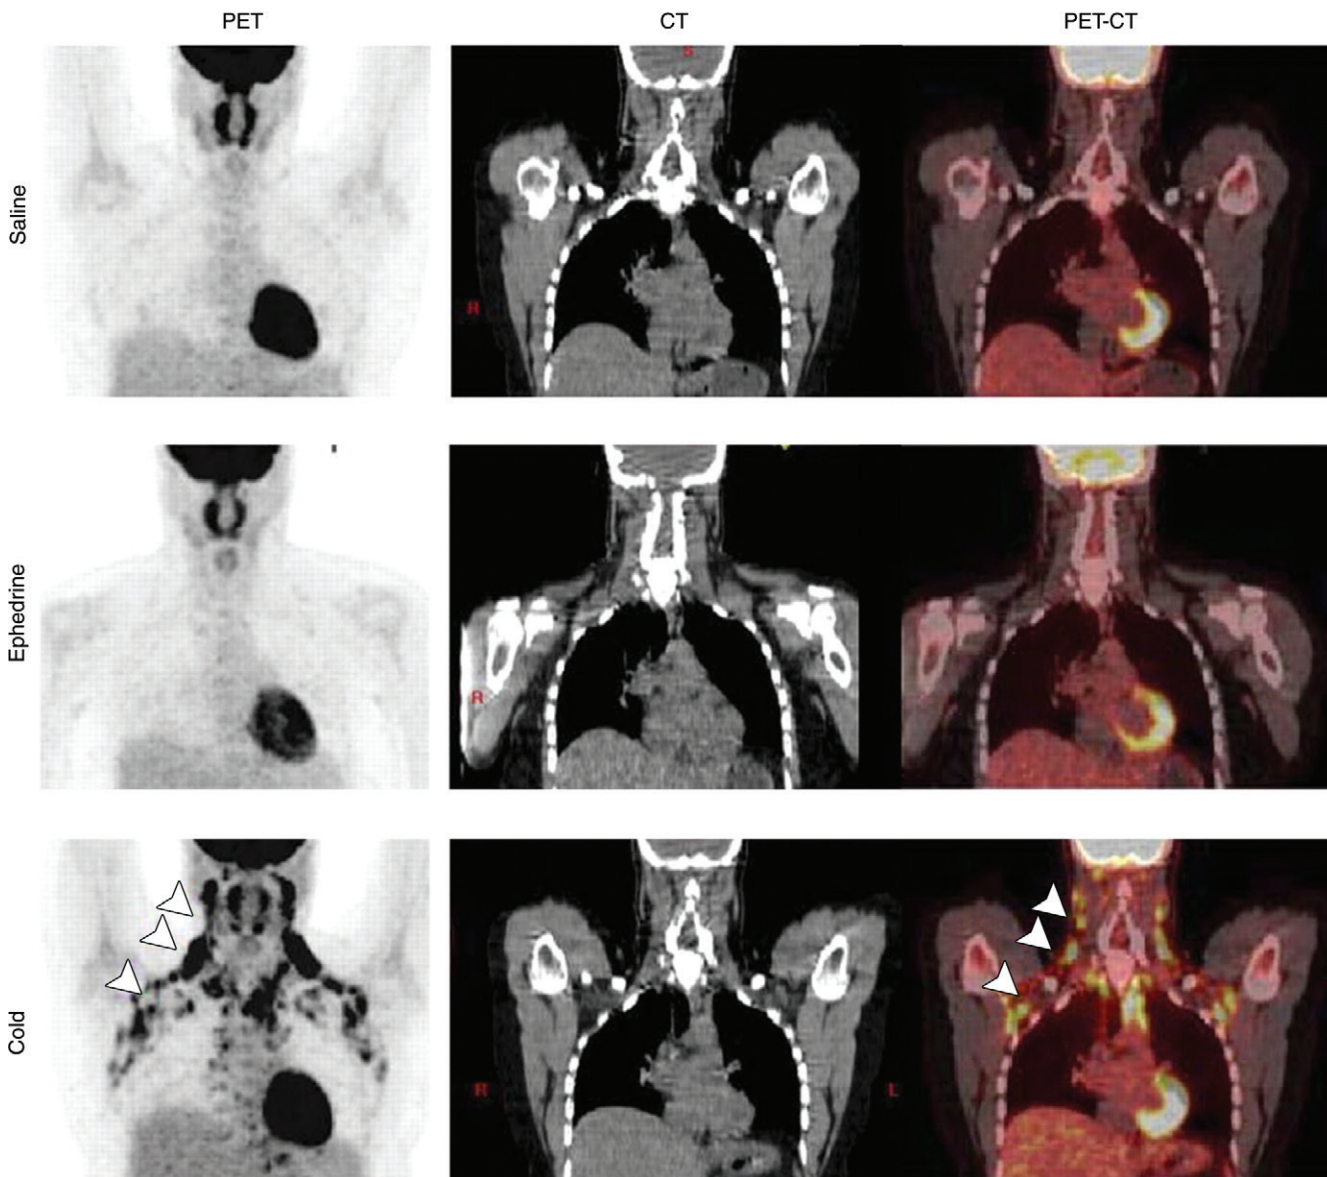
BAT activation induced by means of cold exposure but not sympathomimetic treatment. Coronal ^{18}F FDG PET (left column), CT (middle column), and fused PET/CT (right column) images in healthy volunteer after control saline treatment (top row), ephedrine treatment (middle row), or cold treatment by means of a cooling vest (bottom row). Arrowheads indicate tracer uptake specifically in response to cold treatment. (Reprinted, with permission, from reference 41.)
